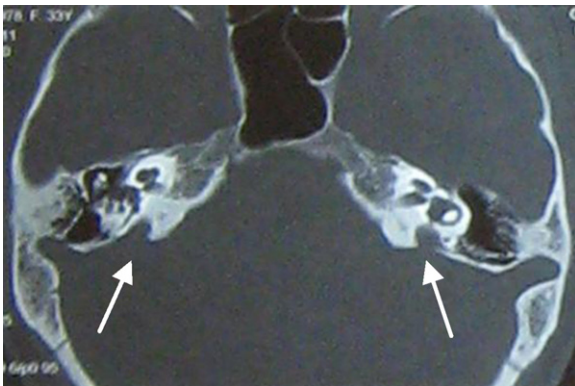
Temporal bone CT scan result of patient IV. 1 (from family IR2). The arrows show enlarged vestibular aqueduct.
